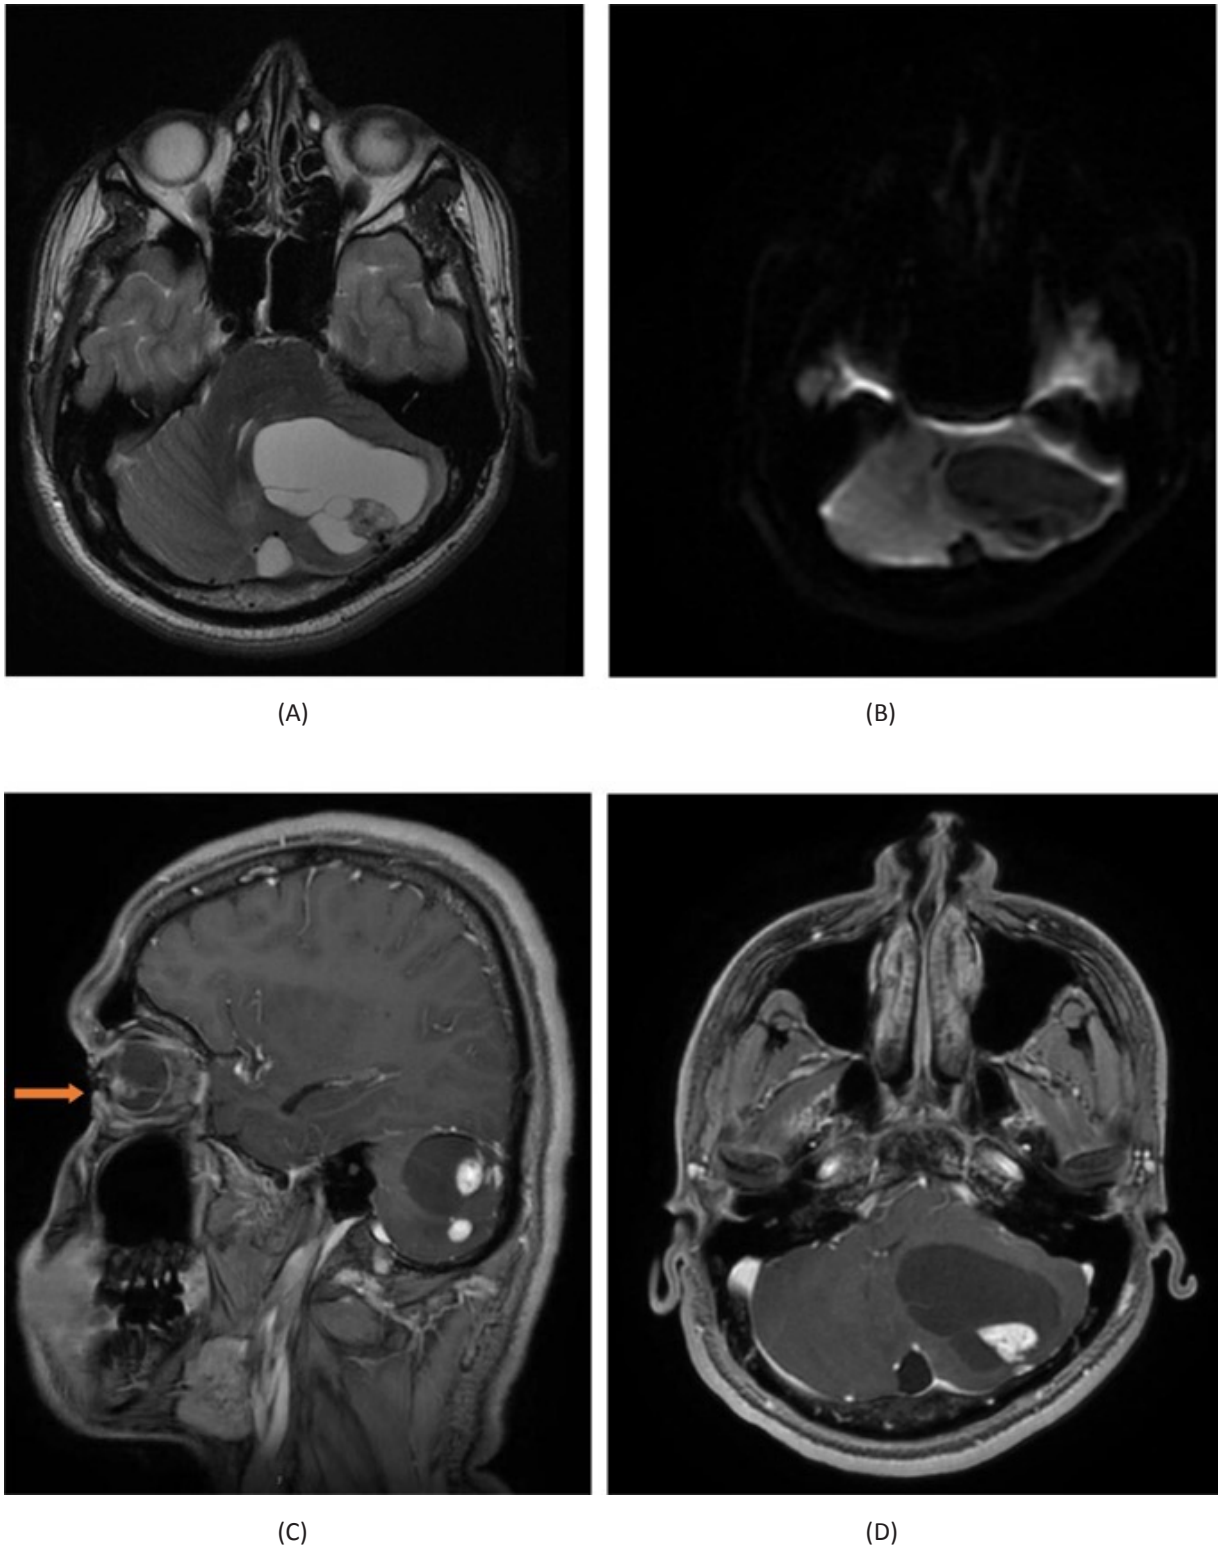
Case of hemangioblastoma. (A): axial T2 shows left cerebellar (off midline) cystic mass with hyperintense nodules, (B): DWI shows no diffusion restriction, (C): left eye angioma (arrow), (D): post contrast sequence shows intense enhancement of the solid component. Patient was a known case of von Hippel-Lindau (VHL) syndrome..
